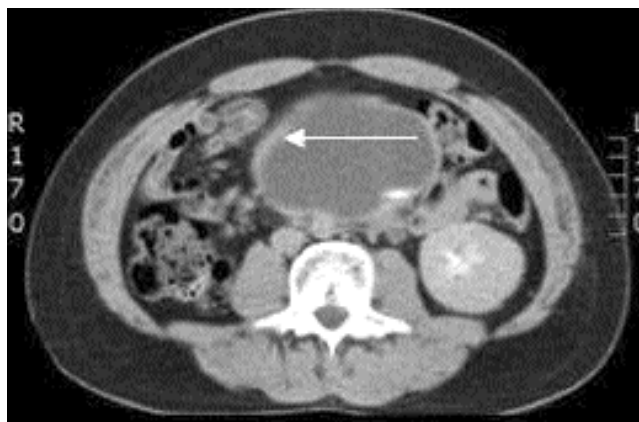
CT scan demonstrating contrast uptake in the periphery of the right crossed ectopic kidney showing it is parenchymal tissue (arrow). This is after the kidney was drained percutaneously.
